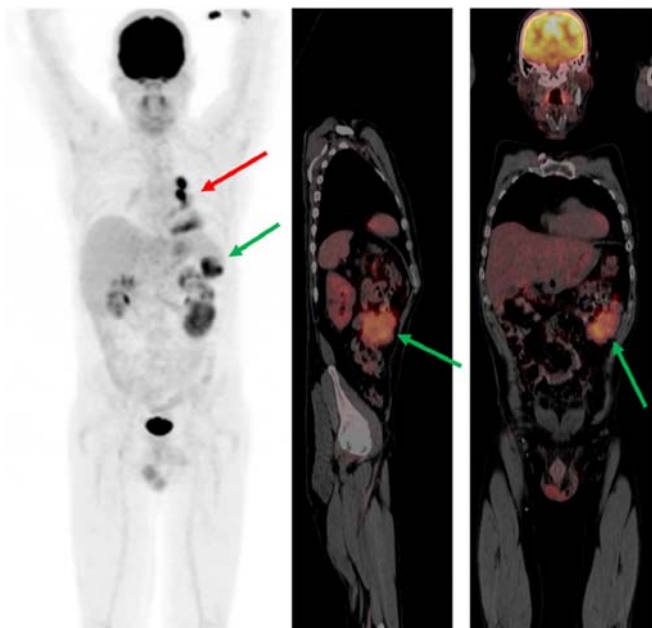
A 48-year-old male with a history of multiple malignant melanoma lesions resected from his right lower limb. Images from FDG PET/CT obtained on account of clinical suspicion of recurrence show large
